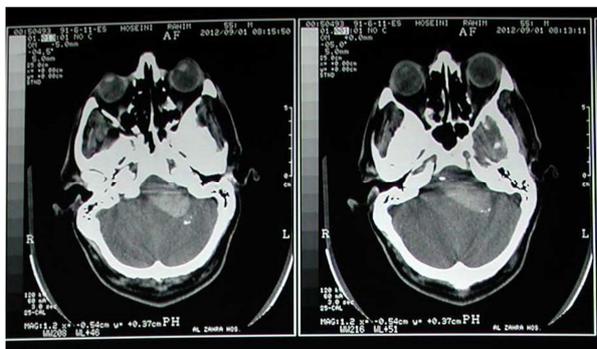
Brain computed tomography scan (CT scan) showing a hyperdense lesion in the brain stem and cerebellum
